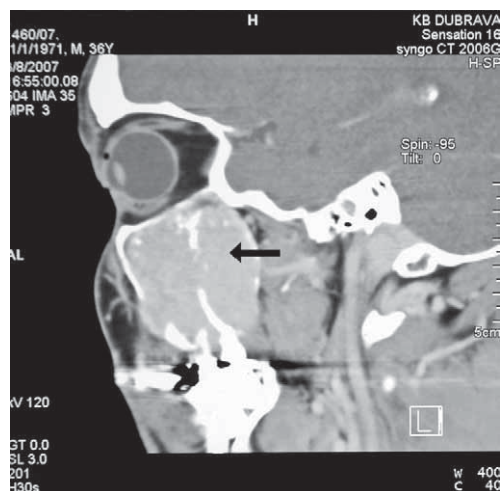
CT-scan showing tumor mass in the right maxillar sinus (sagittal view).
